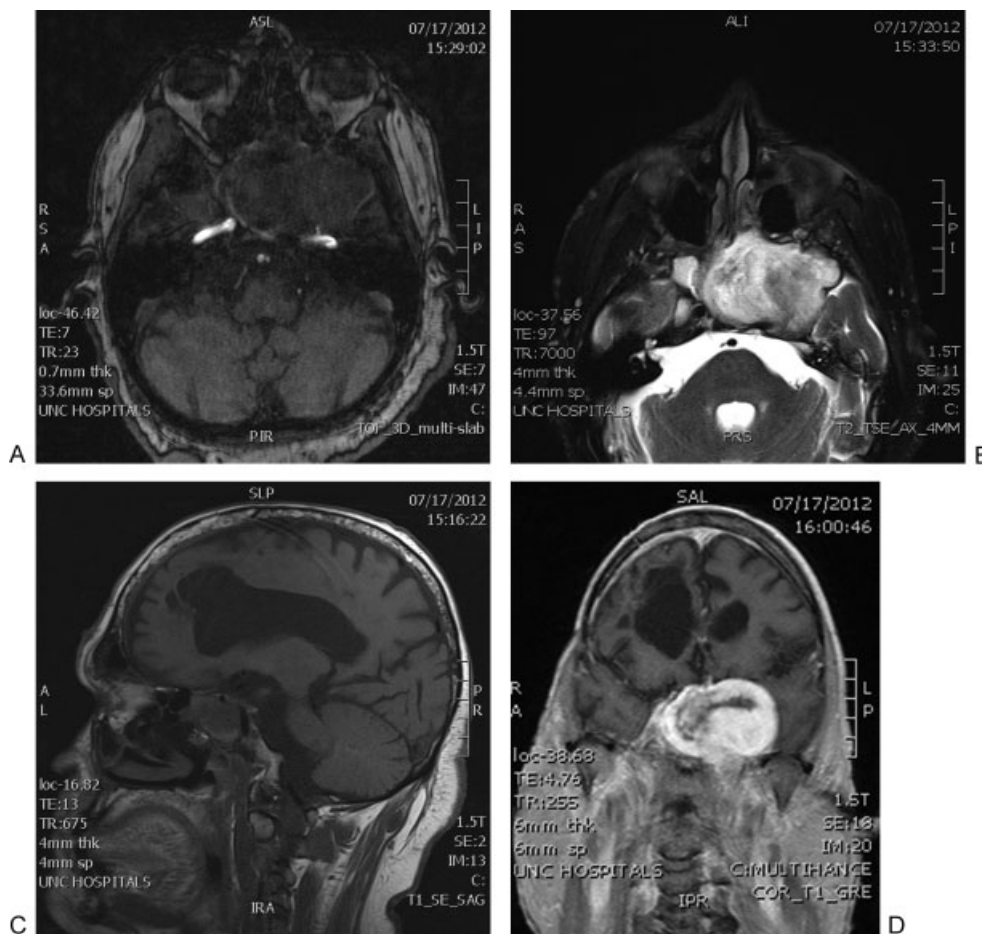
A 43-year-old woman underwent an endoscopic endonasal transclival approach to a 6.2 cm × 4.0 cm left malignant peripheral nerve sheath tumor. The patient presented with a 2-year history of headaches and progressive left-sided vision loss. Preoperative magnetic resonance imaging (MRI) and angiogram revealed tumor extension to the petrous apex and infratemporal fossa with posterosuperior displacement of the petrous and proximal cavernous portions of the left internal carotid artery (ICA) with 45% narrowing at these segments. Magnetic resonance angiography (MRA) also revealed tumor blush arising directly from the ICA. Intraoperative injury to the petrous portion of the left ICA was treated with case cessation and embolization by interventional radiology. During subsequent attempted clip ligation, tumor invasion into the ICA was noted. MRI demonstrated extension of lesion and relationship to left ICA. (A) Axial three-dimensional time-of-flight MRA. (B) Axial T2. (C) Sagittal T1. (D) Coronal T1 sections.
